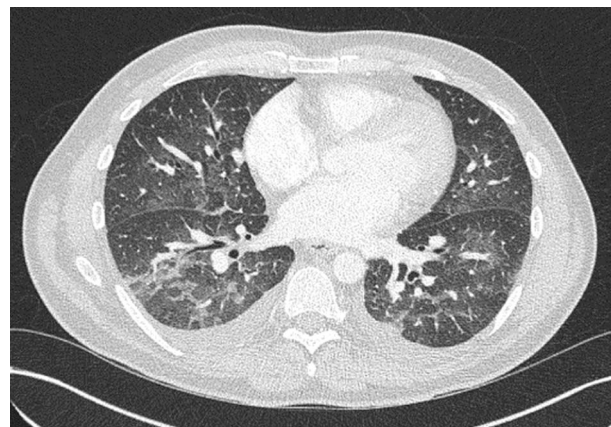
CT-pulmonary angiogram, axial view, demonstrates no pulmonary embolism but diffuse bilateral ground-glass attenuation with thickening of the interlobular septae and small pleural effusions—in addition to mediastinal and hilar lymphadenopathy.
